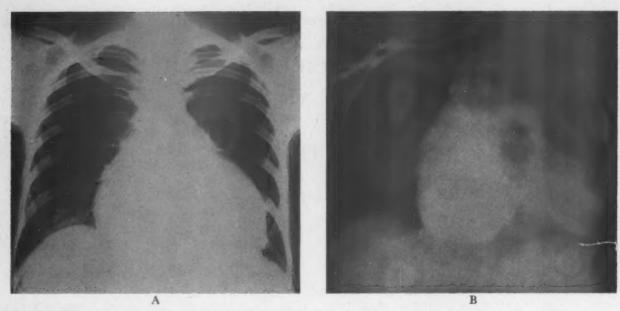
Case 1. A, roentgenogram showing greatly enlarged cardiac shadow and configuration compatible with pericardial effusion. Note diminished pulmonary vascular markings. B, angiocardiogram showing delayed opacification of enormous right atrium and diminished pulmonary vascular markings.
